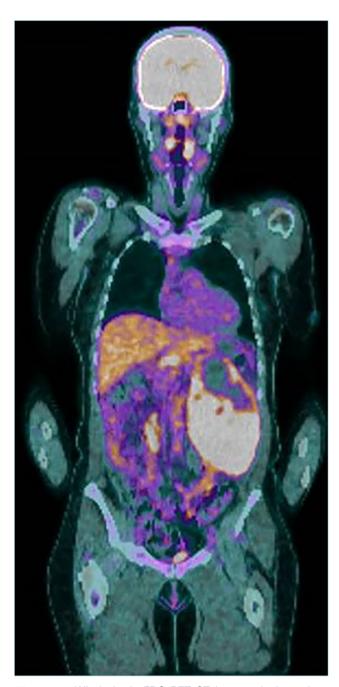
Whole body FDG-PET CT in case 1 showed an FDG avid 17 cm left upper quadrant abdominal mass, with a central area of photopaenia, consistent with necrosis.
